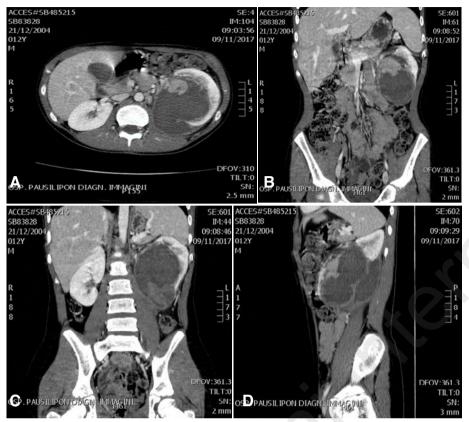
(A-D) - Axial CT images (A), coronal MPR (B-C), sagittal MPR (D) (November 2017): expansive formation of the left kidney, predominantly necrotic with internal vascularized solid tokens. Appreciability of lymph node elements with a max diameter of about 15 mm in the left para-aortic area (A).
